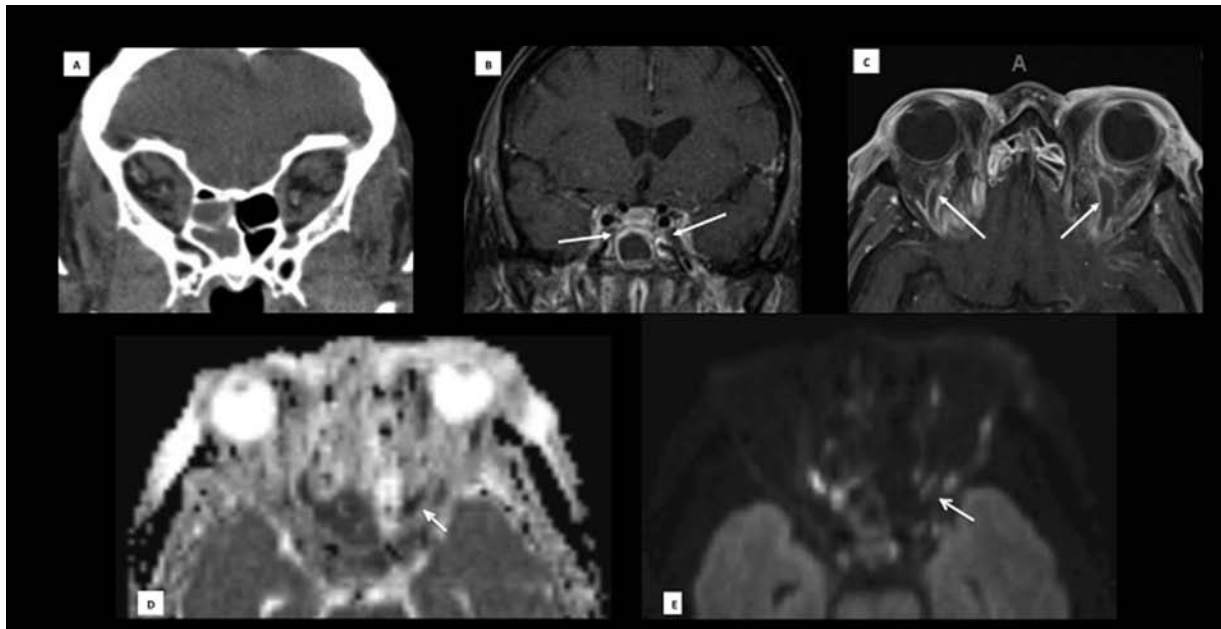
(A) Coronal contrast-enhanced maxillofacial computed tomography scan showing right posterior ethmoid sinus opacification and fat stranding within the right posterior orbit. (B) Coronal T1-weighted contrast-enhanced brain magnetic resonance imaging (MRI) demonstrating enlargement of both cavernous sinuses with convexity of the lateral walls and filling defects (arrows) within the sinuses corresponding to areas of thrombosis. (C) Axial T1-weighted contrast-enhanced orbital MRI showing filling defects within both superior ophthalmic veins (arrows). (D) The axial diffusion-weighted MRI and (E) the corresponding diffusion coefficient map demonstrating restricted diffusion in the left optic nerve (arrows).
